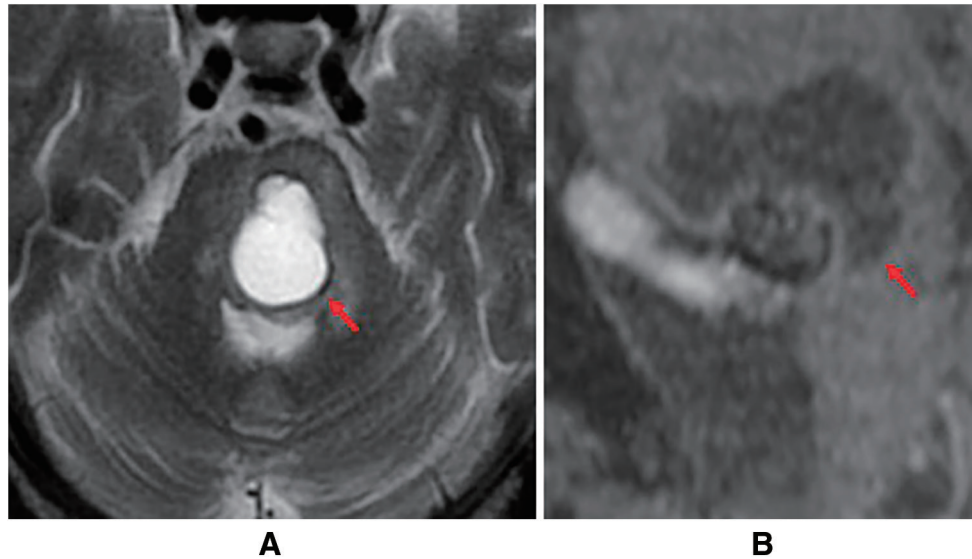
Fifteen months after embolization, FLAIR (A) showing edema and cyst formation around the aneurysm (arrow). The T2-weighted image (B) showing the iso-intensity cyst with the cerebrospinal fluid (arrow).
